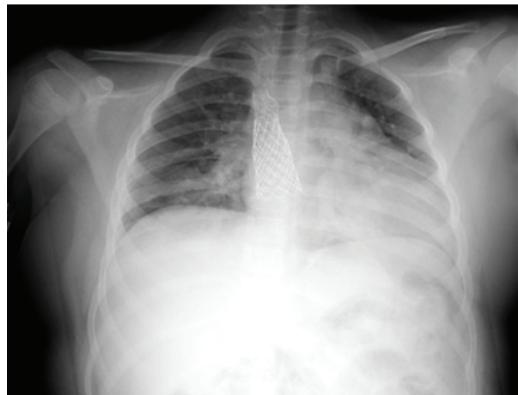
X-ray 24 hours post procedure confirmed stent in position.
